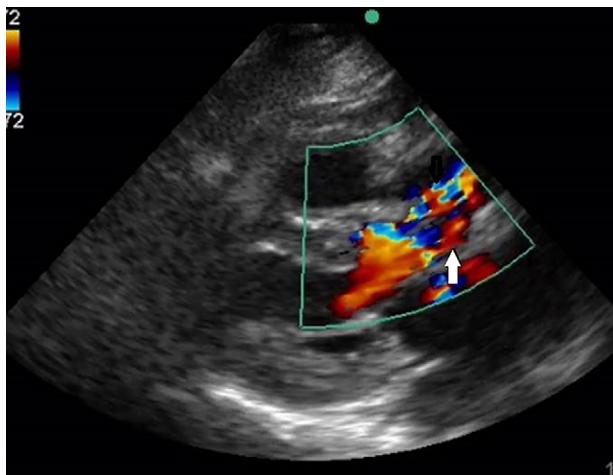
Parasternal long-axis window flow analysis. Arrow shows swirling flow through stented valve.
